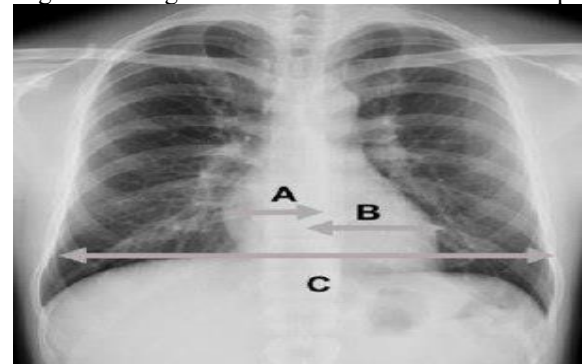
Shows the method of calculating the CTR on a chest X-ray by measuring cardiac width (a+b) and thoracic width (c).
